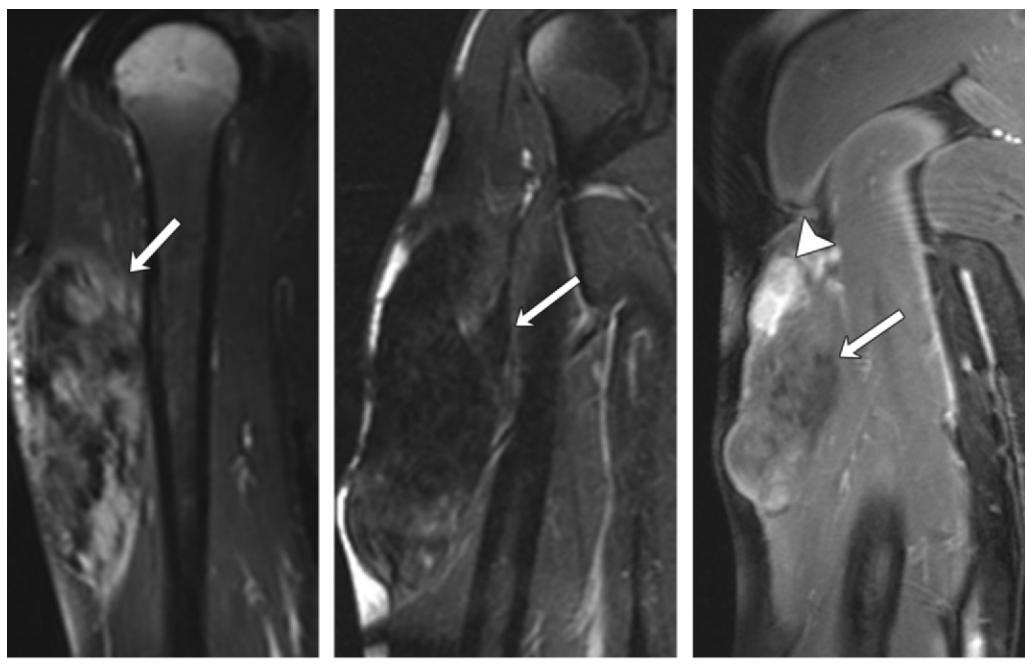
Positive treatment response to chemotherapy with imatinib of an unresectable sporadic extra-abdominal DF of the right triceps region in a 22-year-old man. (a) Coronal contrast-enhanced fat-suppressed T1-weighted MR image (550/18) at diagnosis shows a heterogeneous avidly enhancing intramuscular mass (arrow) in the right arm. (b) Coronal contrast-enhanced fat-suppressed T1-weighted MR image (800/14) after 2 years of systemic therapy with imatinib demonstrates slight interval increase in tumor (arrow) size but a marked decrease in enhancement. (c) Coronal contrast-enhanced fat-suppressed T1-weighted MR image (14/5), 24 months after cessation of imatinib therapy, reveals a new nodular enhancing focus (arrowhead) along the superior aspect of the tumor (arrow), indicating an aggressive component of the tumor.
